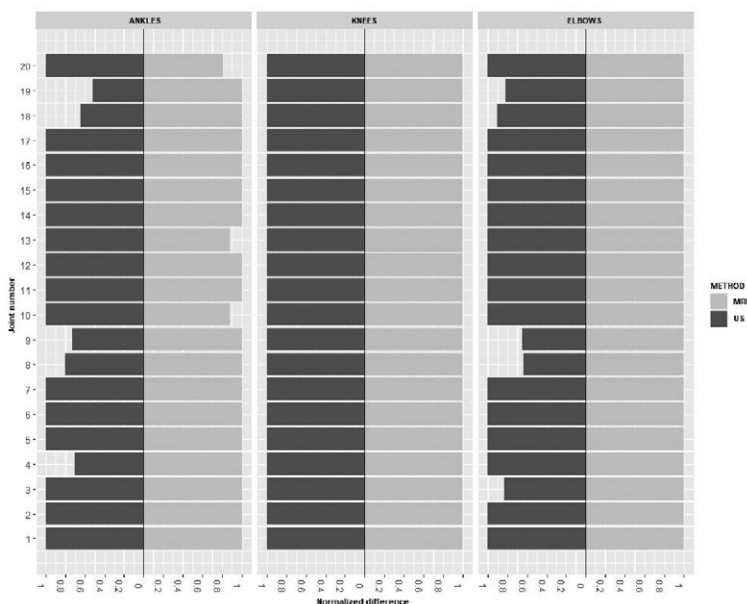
Concordance plot for depicting agreement between US and MRI scores for all three joints. Equal size of the fields denotes perfect agreement. The plots demonstrate overall an excellent agreement between the methods. It can also be observed, that in most cases of discordance, US slightly undervalued the progression of the joint disease.
